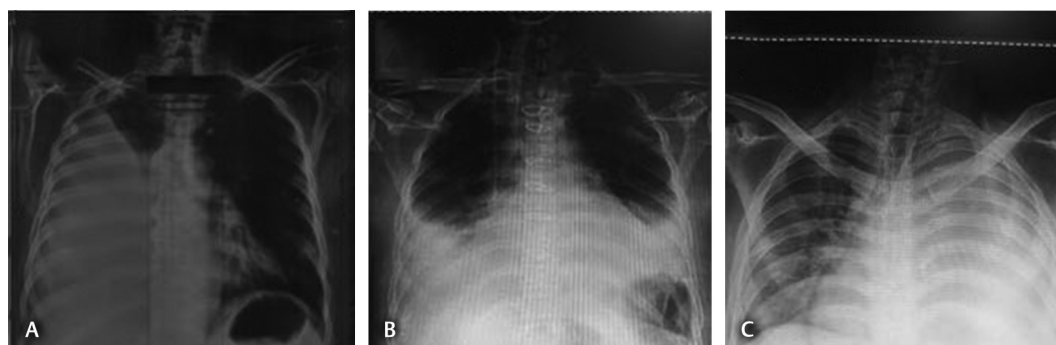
Chest X-rays: (A) right-sided pleural effusion, (B) left-sided pleural effusion, and (C) bilateral pleural effusion.
